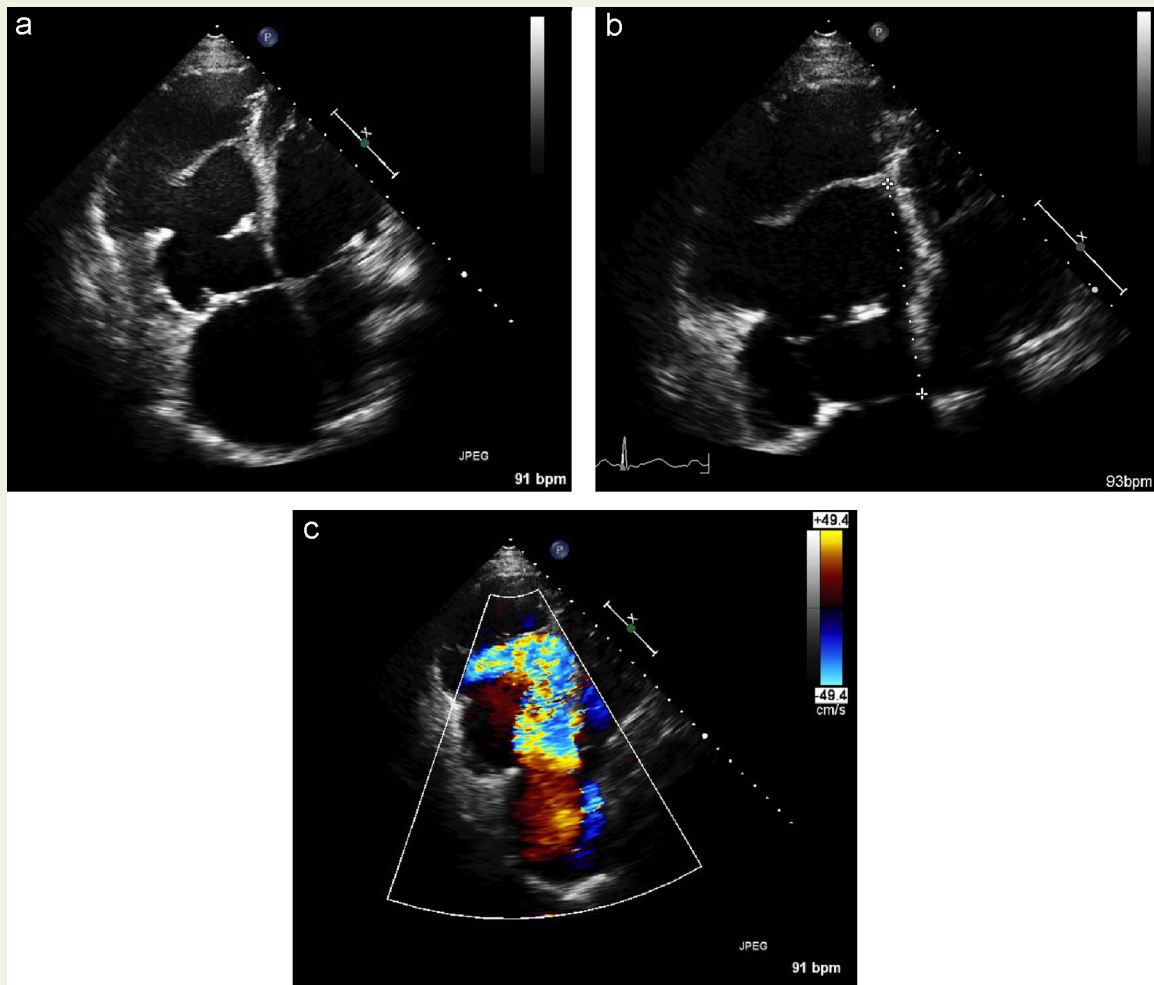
Apical four-chamber images demonstrating severe apical tricuspid valve displacement consistent with known Ebstein's anomaly (Figures 1a and 1b). There is severe tricuspid valve incompetence as noted in Figure 1c.
